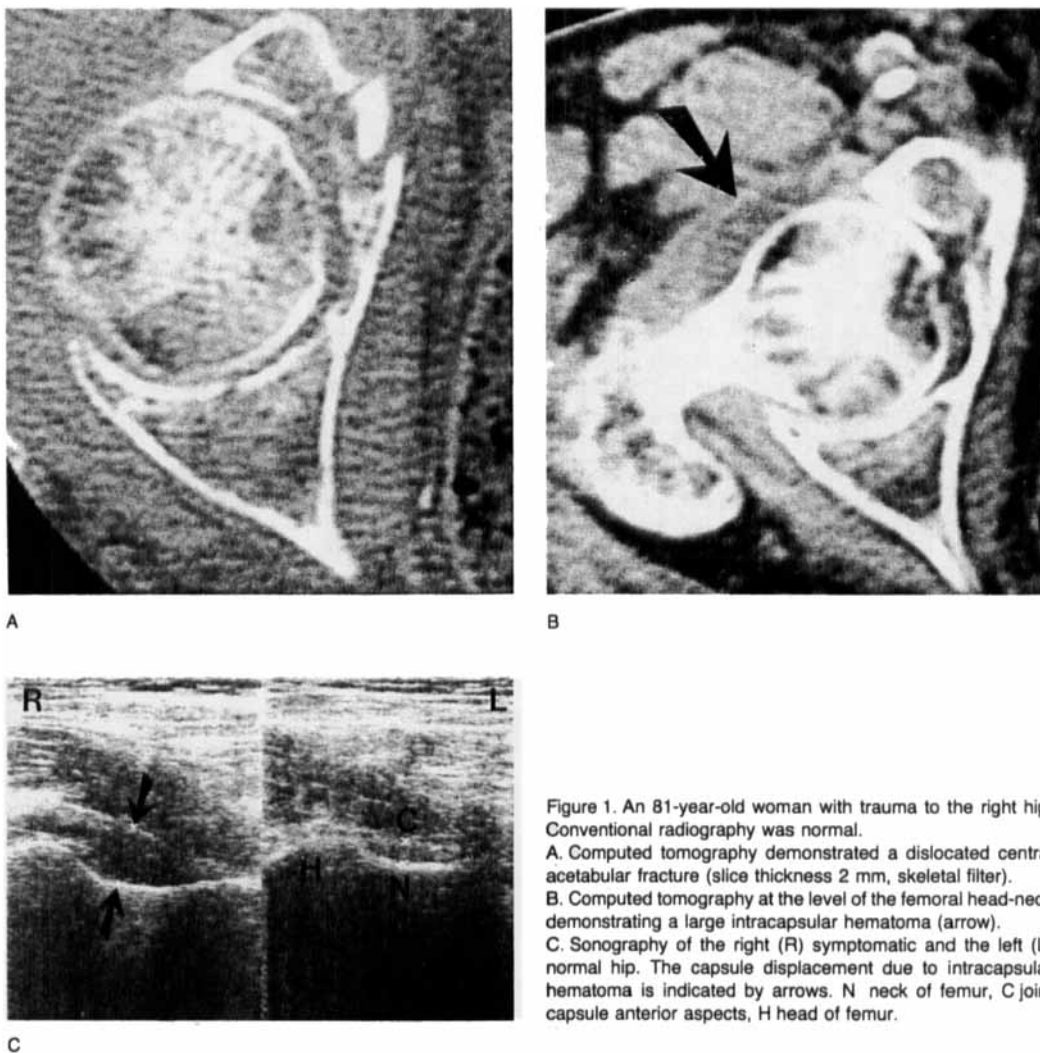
An 81-year-old woman with trauma to the right hip. Conventional radiography was normal.
